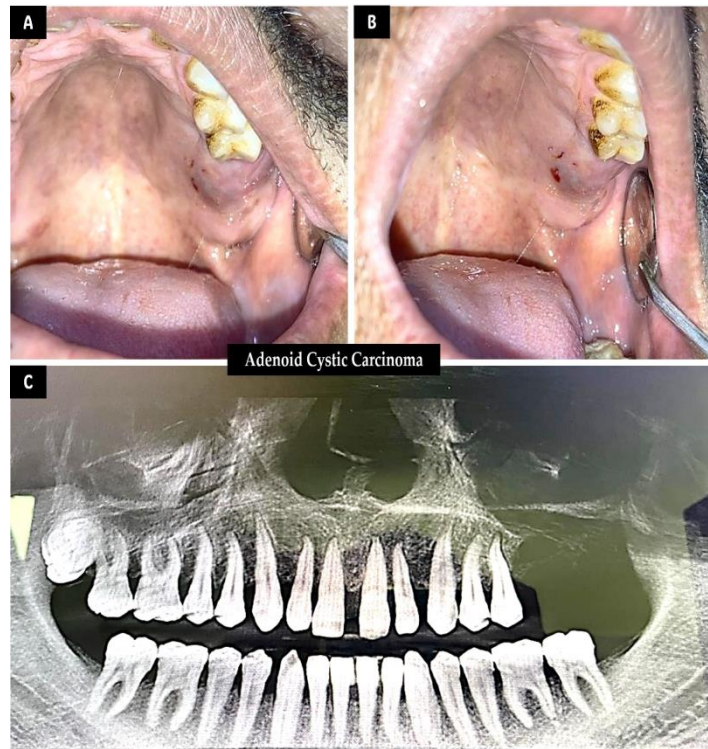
(A) Intra oral picture of maxillary arch showing the growth in the region of maxillary tuberosity (B) the overlying mucosa on the growth showing changed color of mucosa (C) orthopantomograph showing a wide tumor on the left side with loss of bony structures.
